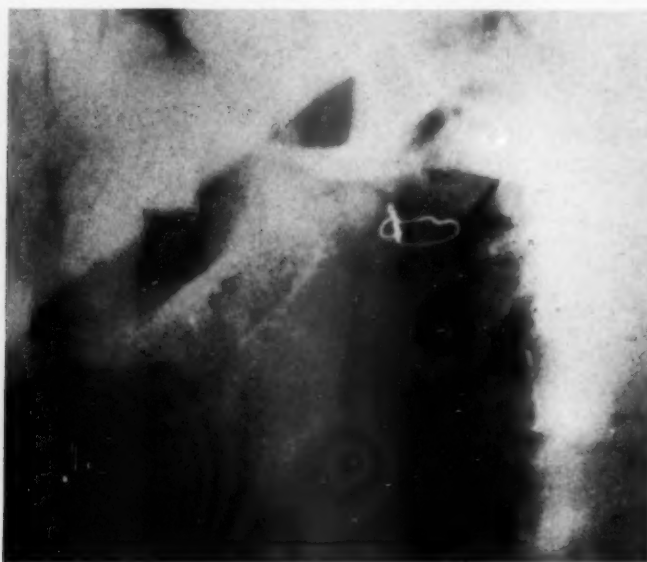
Lateral x-ray showing internal wiring fixation.
